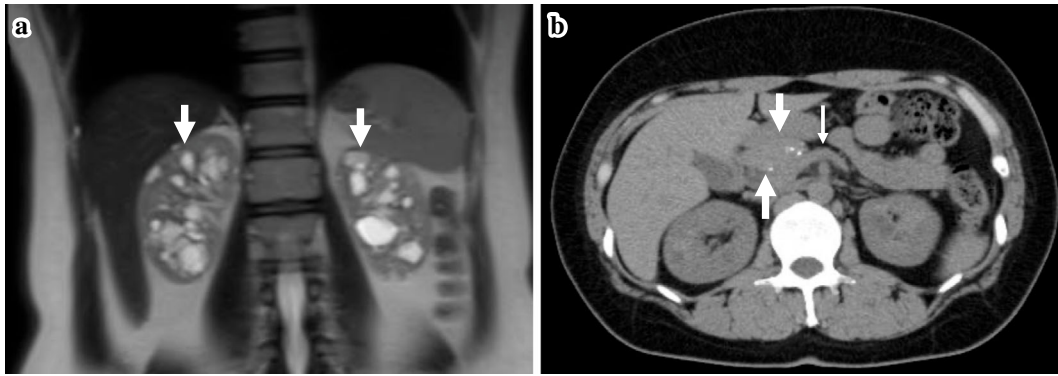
Magnetic resonance imaging and computed tomography findings. a: T2-weighted image of magnetic resonance imaging showed multiple cysts with hyperintensity (arrows) compared to the adjacent fat area in the renal medullary area. b: Computed tomography showed calcification of the pancreatic head (large arrows) but hypoplasia of the pancreatic body or tail (small arrow).
